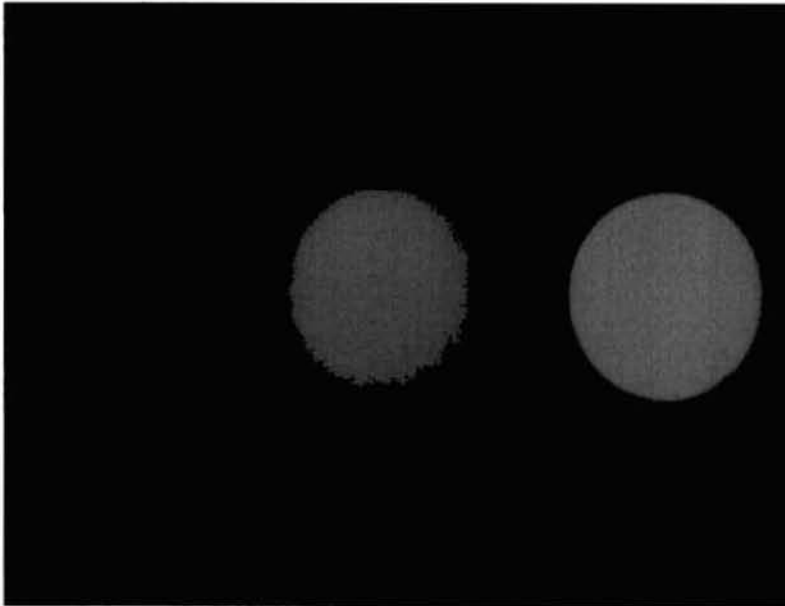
X-ray photographs of NR-ZnO systems at concentrations varying from 50 - 150 phr
